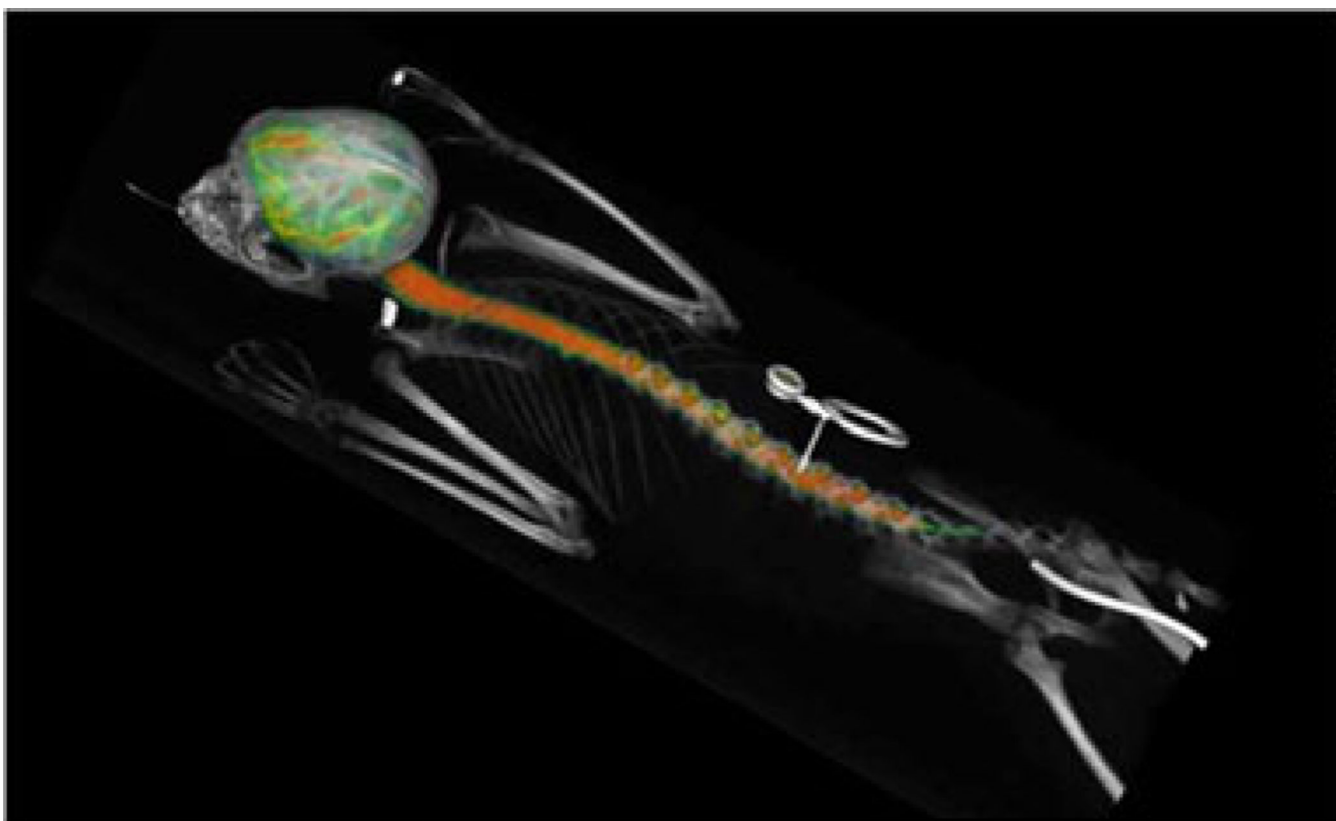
Protein distribution 3 h after ITL administration through a subcutaneous port (*center*) connected through a subcutaneous catheter with the leptomeningeal space. PET/CT image. Color represents 3D map of the protein concentration as measured by PET
